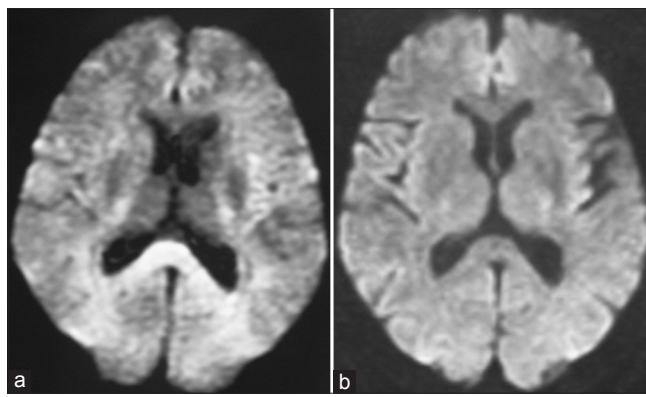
(a) Boomerang-shaped high signal intensity was detected in the splenium of the corpus callosum on diffusion-weighted MRI (b) The lesion had disappeared on MRI on the next day with the recovery from hypoglycemia
